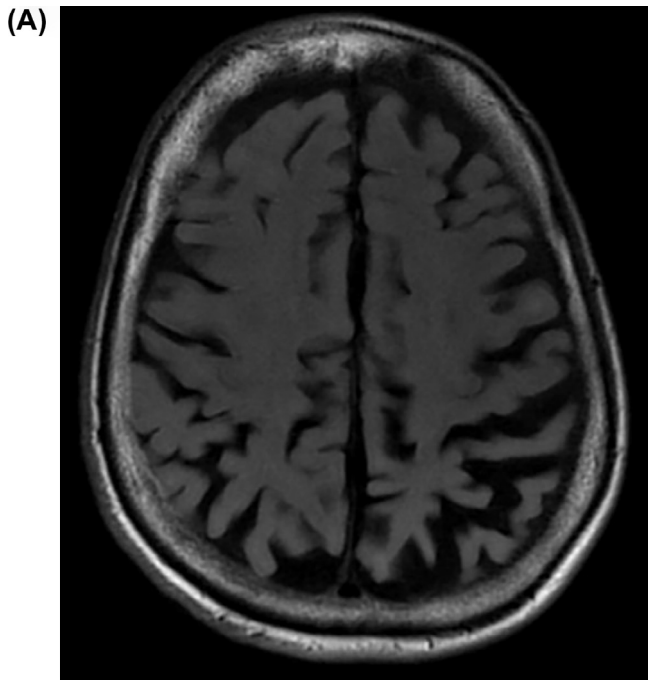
An axial (A) and coronal (B) T2-weighted brain MRI showed atrophy of the left parietal lobe out of proportion to that seen in the right hemisphere.
